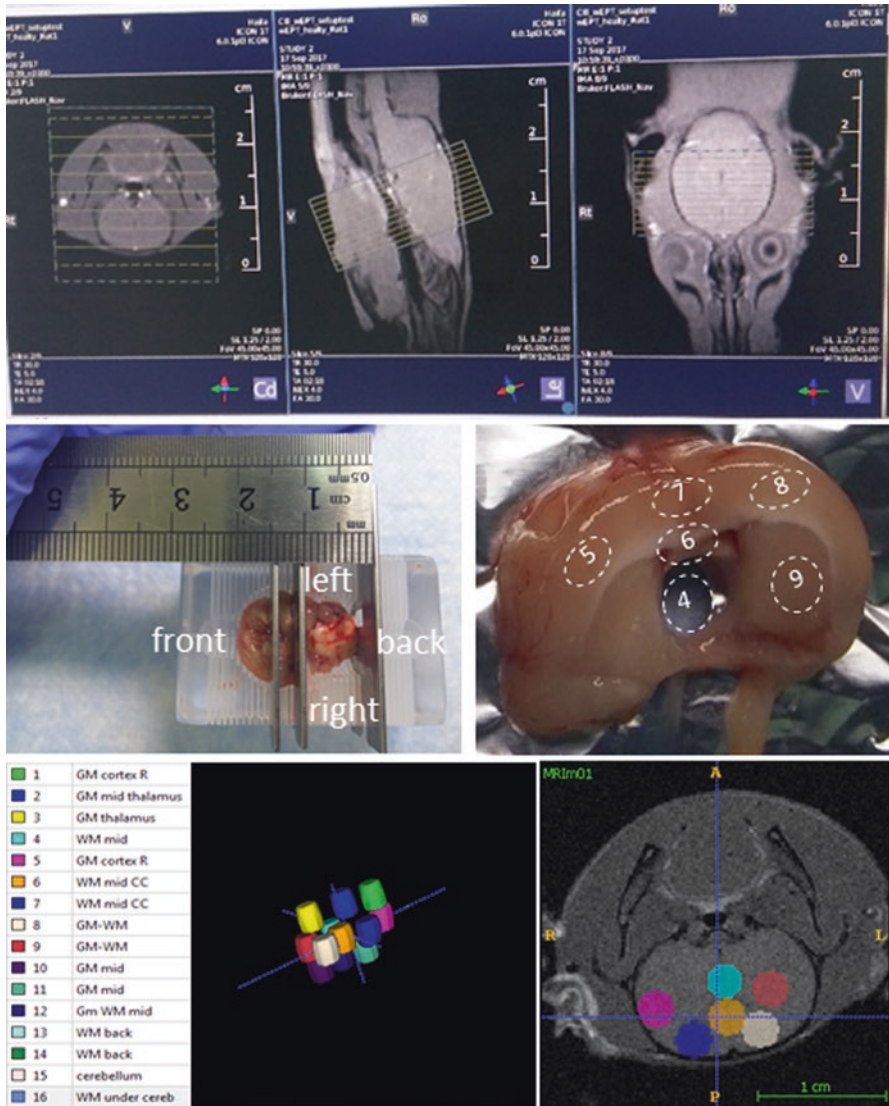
Experimental procedures in healthy rat1. (top) The in vivo MRI localization of the brain in axial, coronal, and sagittal views. (middle) Excised brain in the brain slicer and slice of mid-brain, where one sample with id = 4 is already punched out. The locations of five additionally planned punch sites are indicated. (bottom) Corresponding sample segmentation in ITK-Snap along with a 3D rendering of 12 tissue samples with their labels and one corresponding slice through samples with the same id = {4-9}
